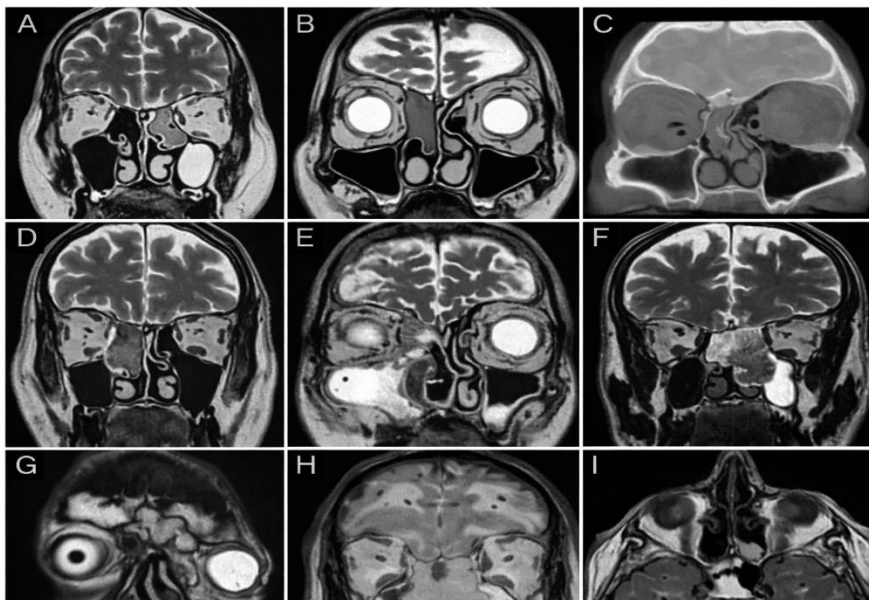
Several Patterns of Loco-Regional Expansion Of MRI-Scanned Sinus Carcinomas Are Summarised (Ferrari et al., 2021).
